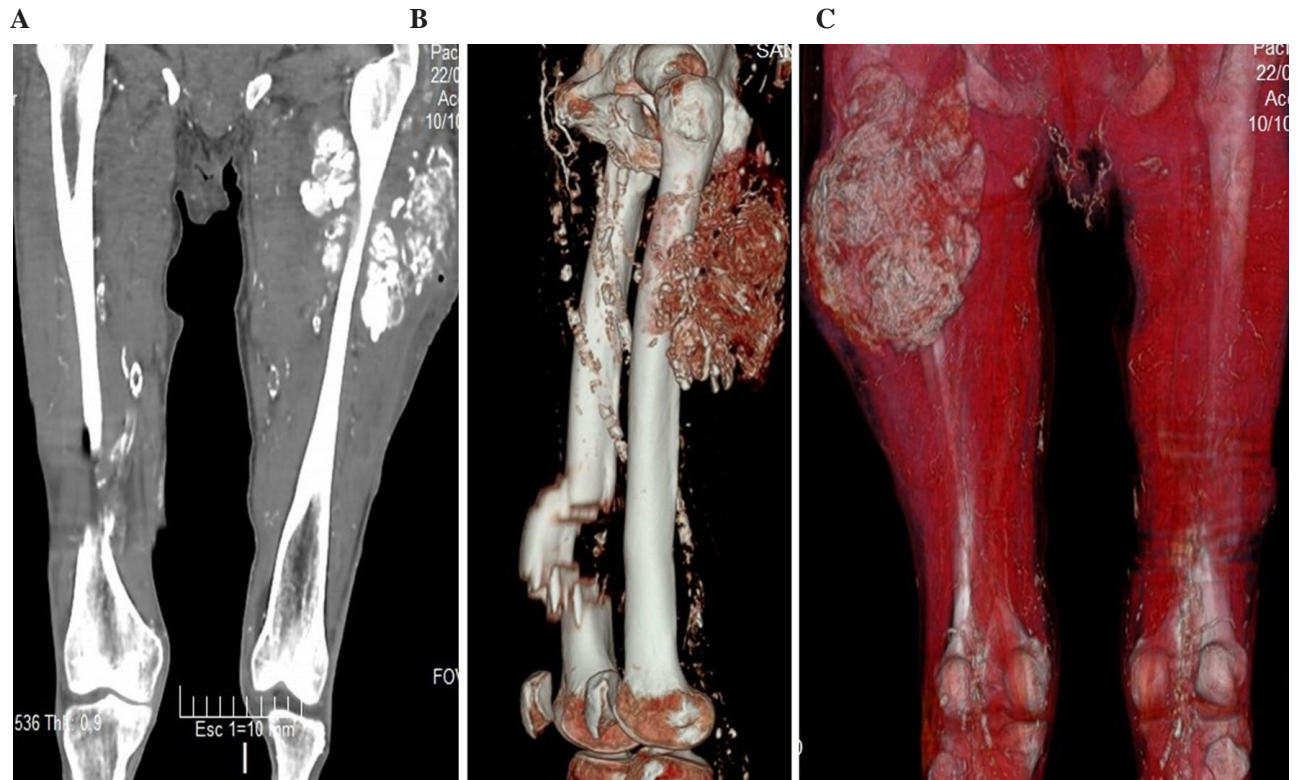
Simple thigh CT-scan. A. An image compatible with calcium density is observed in the left thigh. B. Lateral image with reconstruction of the bone, where calcification of femoral arteries is observed. C. Reconstruction of tissues where the calcium mass is observed in the thigh, as well as calcification of spermatic arteries.
